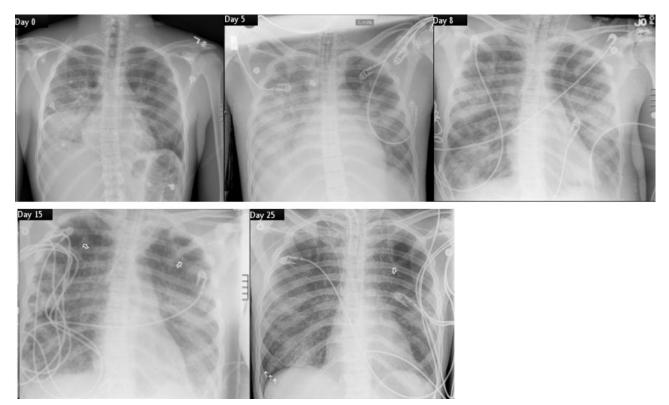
Representative chest radiographs that show the evolution of ventilator-induced lung injury. On days 0 and 5, when the patient was on pressure control continuous mandatory ventilation, there is no evidence for ventilator-induced lung injury. However, hyperinflation of the left lung is evident. On day 8, after 3 days of ventilation in APRV/BiLevel, areas of hyperlucency are evident on both sides. By day 15, cystic changes are evident (open arrows). Day 25 shows progression of lung injury with pneumothorax on the lower right side (3 arrows).
